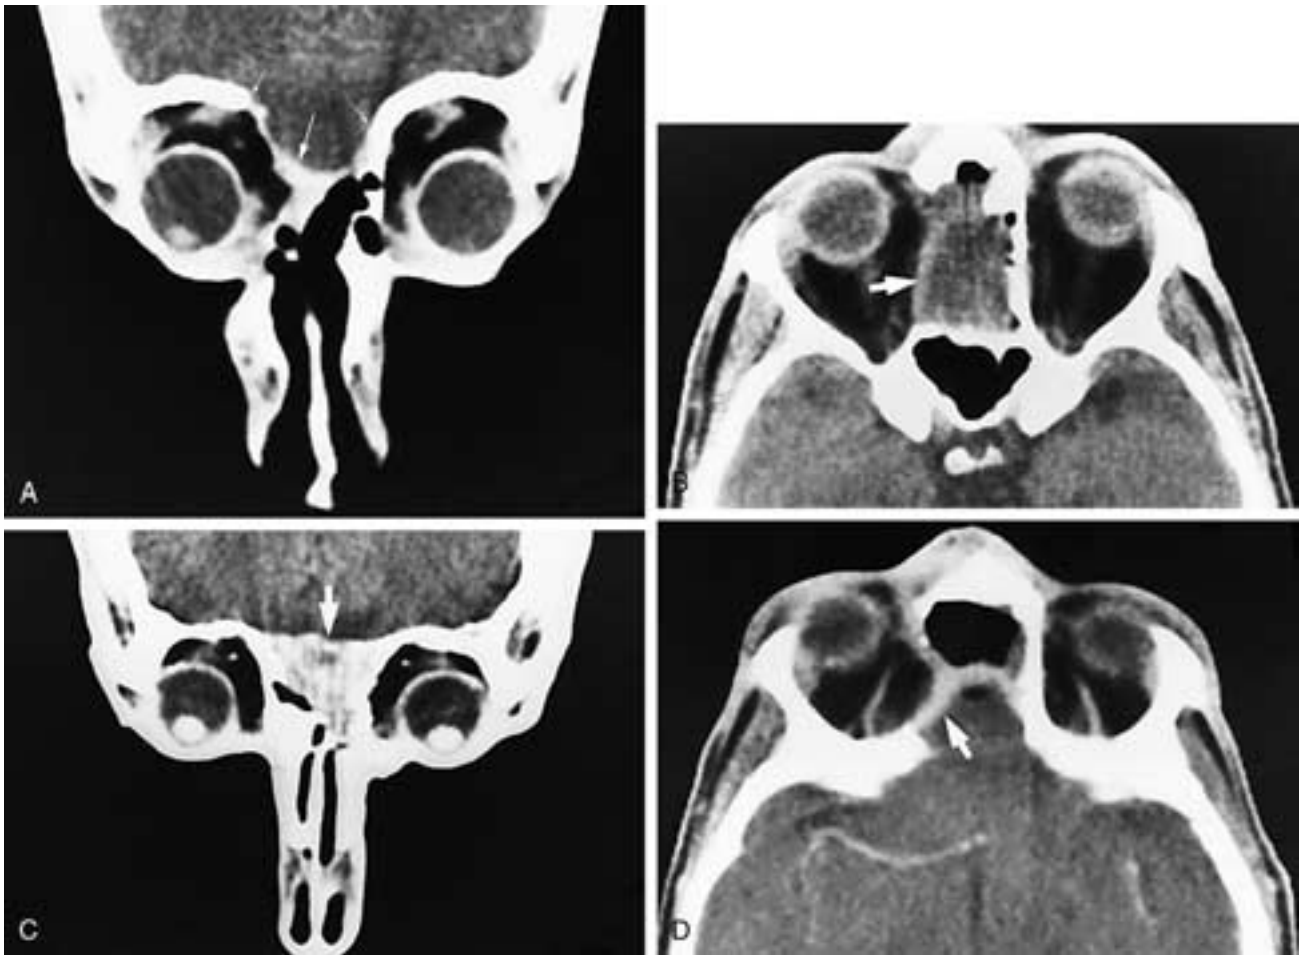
Coronal contrast-enhanced CT scan (A) on a patient who has had a craniofacial procedure. There is enhancement of the muscle fascial graft (*large arrow*) between the margins of the bony resection (*small arrows*). The intracranial and sinonasal contours of the graft are smooth. Axial CT scan (B) shows a soft-tissue mass (*arrow*) in the postoperative upper nasoethmoid cavity. This is the fascial-muscle graft of an osteoplastic flap as it prolapses slightly below the level of the anterior skull base. Any confusion regarding this “pseudomass” can be resolved with a coronal study. Coronal contrast-enhanced CT scan (C) on a patient who has had a craniofacial resection. The fascial-muscle graft and adjacent dura enhance (*arrow*), filling the surgical defect in the floor of the anterior cranial fossa. The graft hangs down into the postoperative nasoethmoid cavity. Axial contrast-enhanced CT scan (D) shows enhancement of dura and granulation tissue (*arrow*) partially below the level of the fascial-muscle graft in a patient who has had a craniofacial resection. The air anteriorly is actually in the upper postoperative nasoethmoid cavity.
